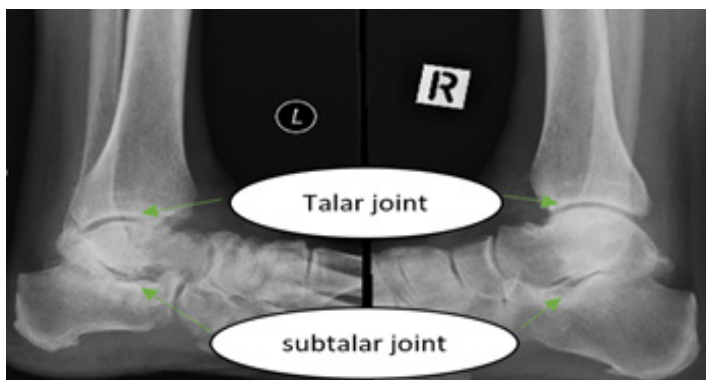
Pre- stem cell therapy x-ray shows bilateral severe osteoarthritis subtalar and mild talar OA.
